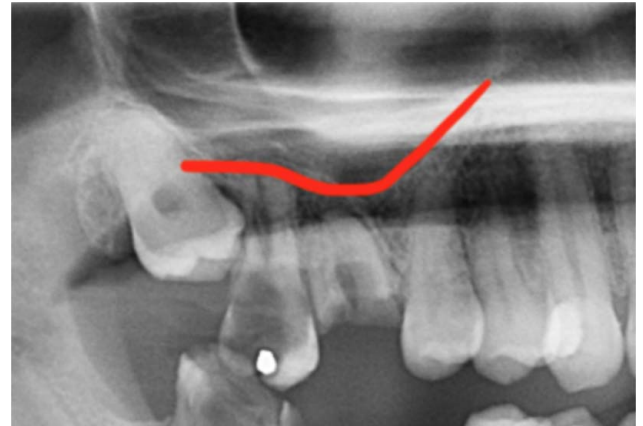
Pretreatment radiograph demonstrating pneumatization of the maxillary sinus with failing dentition.
